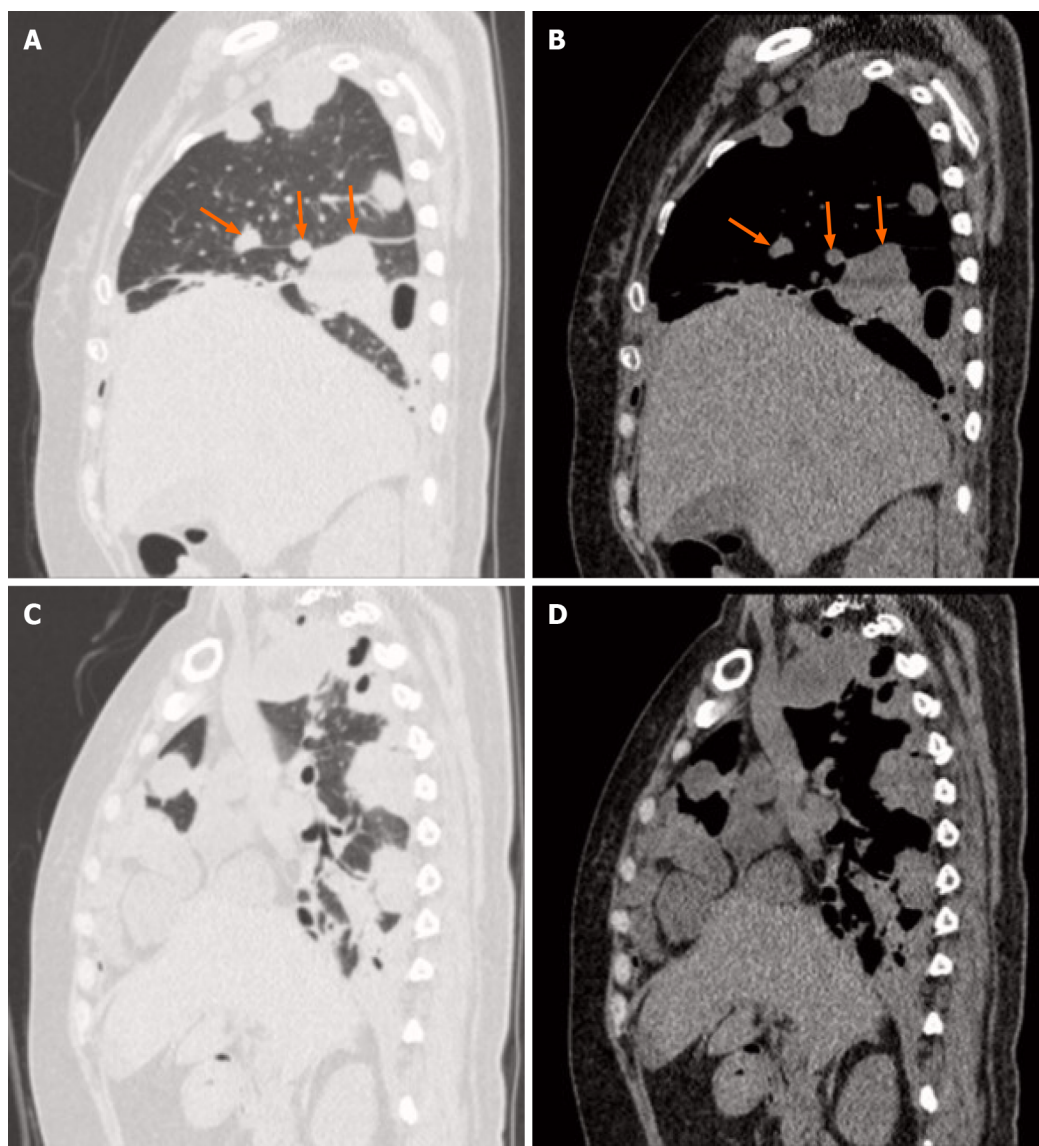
Sagittal computed tomography showed many nodular or hillock lesions in the right pleura, mediastinum, and interlobar fissure areas. A and B: The lesions were located in the right pleura and interlobar fissure areas (arrow); C and D: The lesions were located in the right pleura and mediastinum areas.
